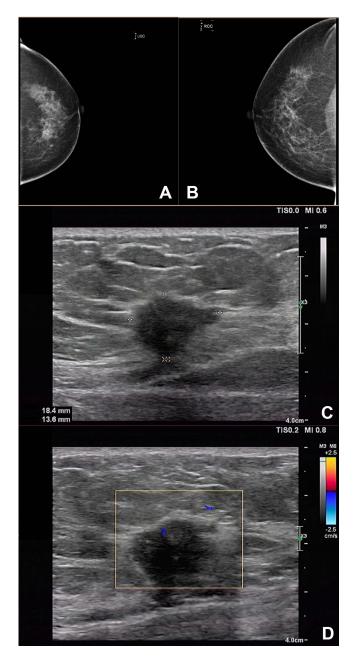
Results of another patient tested positive for breast carcinoma. (A and B). Molybdenum target X-ray results. (C and D). High-frequency color Doppler flow imaging (CDFI) results.
